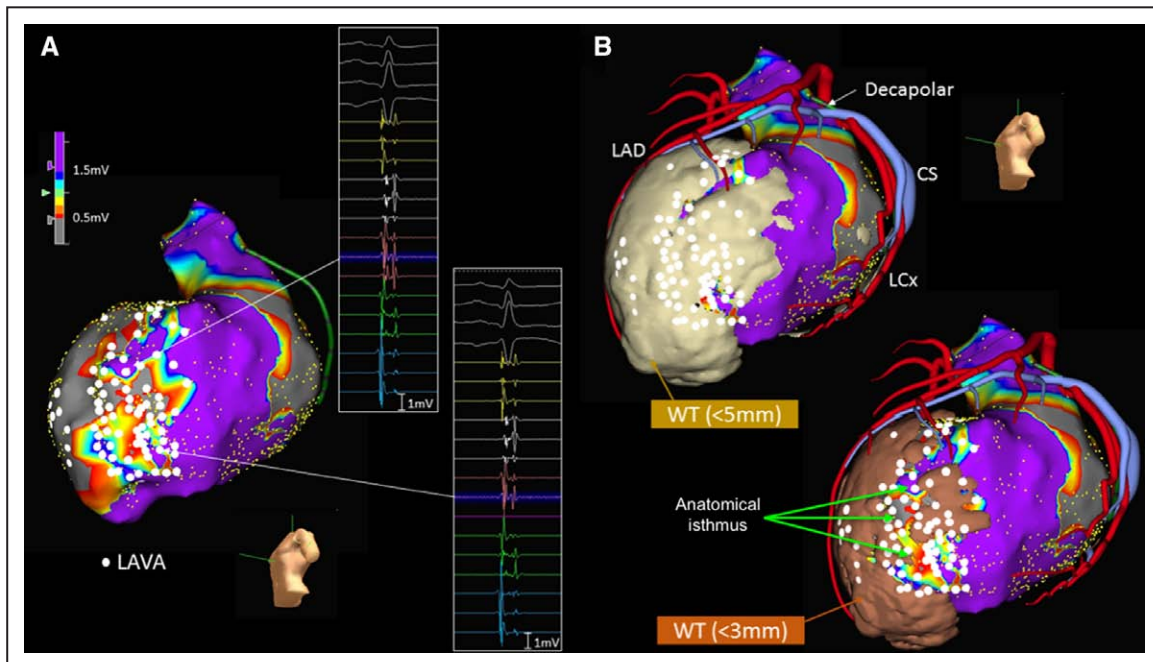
High-density mapping and real-time image integration. A case of post-myocardial infarction ventricular tachycardia (post-MI VT; 60 y; man) is shown. A, Voltage map demonstrates large scar on anterior left ventricular (LV) wall with local abnormal ventricular activity (LAVA) as recorded by a multipolar catheter. B, Image integration from multidetector computed tomography provides anatomic details including the course of coronary arteries (red) and coronary sinus (CS) branches (blue). A decapolar catheter (green) is placed in distal CS to monitor image registration. Anatomic substrate demonstrated as areas of moderate and severe wall thinning (WT; light and dark brown surfaces). An anatomic isthmus of moderate WT is visible (green arrows), hosting most LAVAs, many of which show normal voltage (>1.5 mV). LAD indicates left anterior descending artery; and LCx, left circumflex artery.
